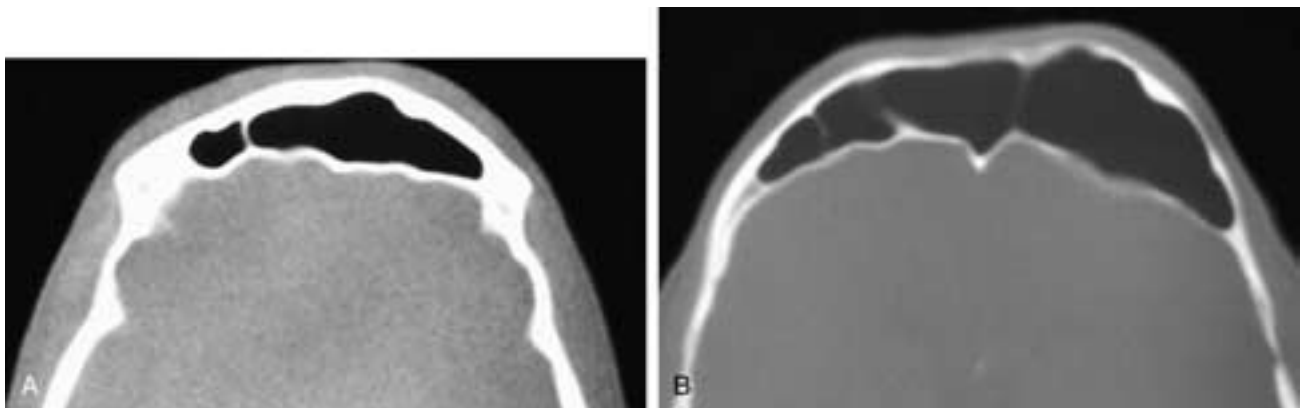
A, Axial CT scan shows an enlarged left frontal sinus that has not thinned the bone of either the anterior or posterior sinus walls. However, the anterior wall has been minimally bowed forward, causing a bulge in the forehead. This patient had a pneumosinus dilatans. B, Axial CT scan on another patient shows a very large frontal sinus with anterior bowing of the anterior sinus table. This patient also had pneumosinus dilatans.
